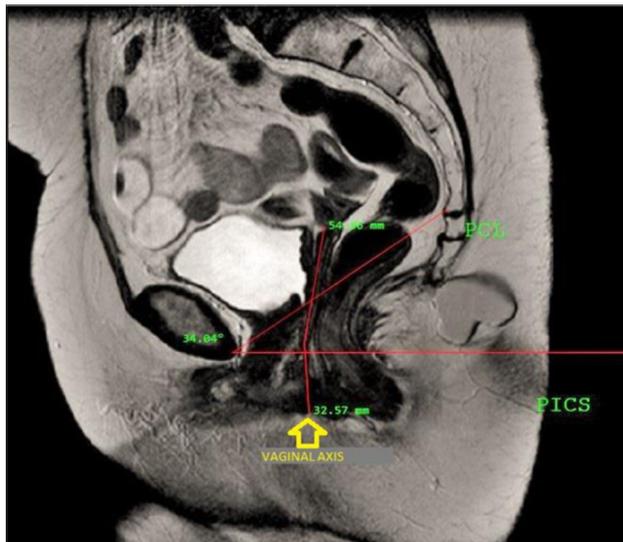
sagittal view on pelvic MRI. PICS: pelvic imaging correction system. PCL: pubococcygeal line. Vaginal axis: line drawn through the vaginal walls, divided in two sections (superior and inferior vaginal axes)
